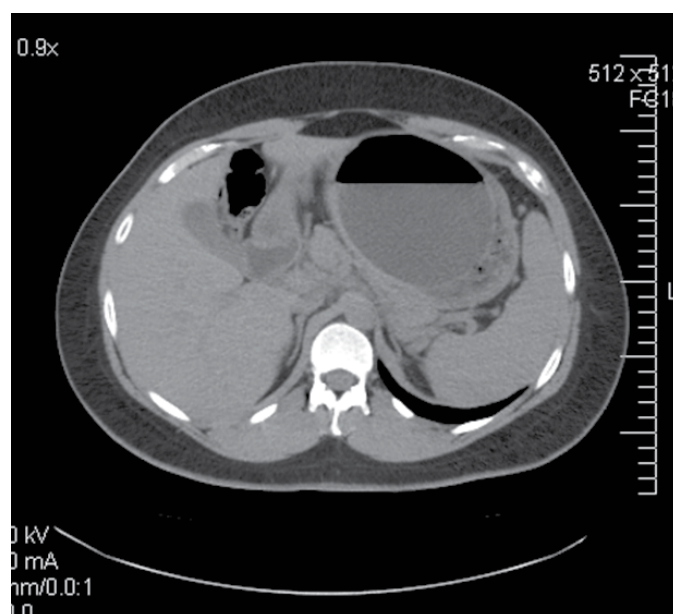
Computed tomography scan of the abdomen showing edema in the tail of the pancreas.
